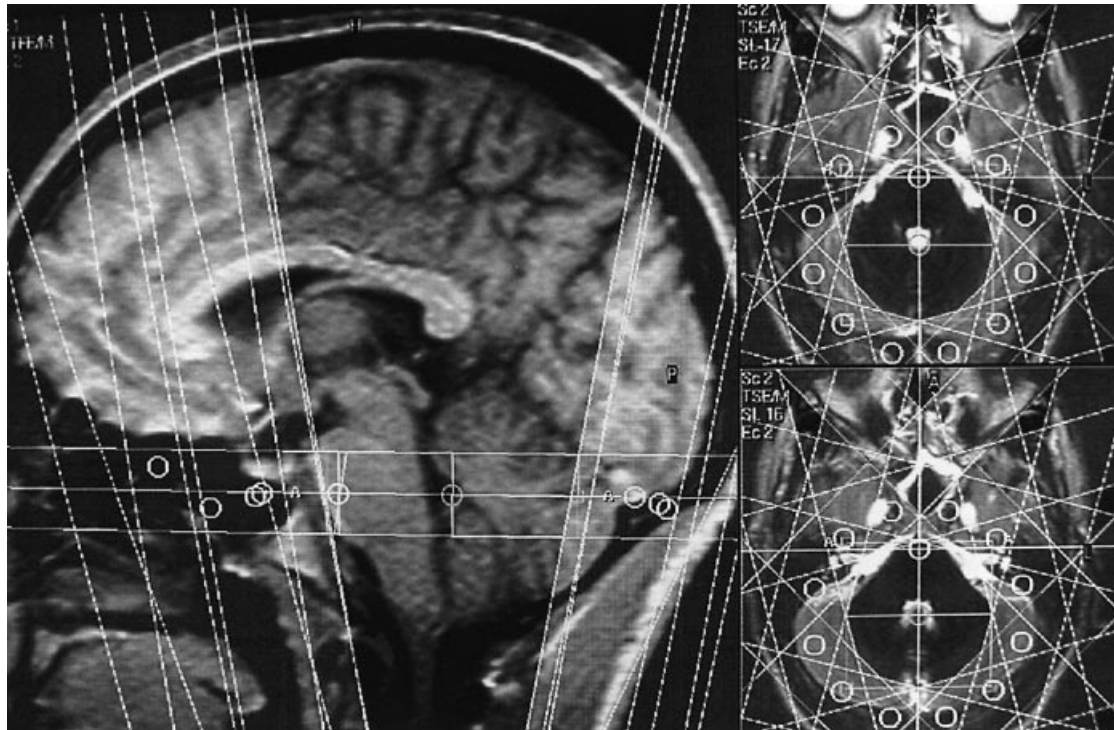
Slice locations for ^1H -MRS of the cerebellum and brainstem, overlaid on midsagittal (left) and transversal (right) T1 and T2-weighted localizer images. The 12 saturation slabs perpendicular to the acquisition plane are also shown.
